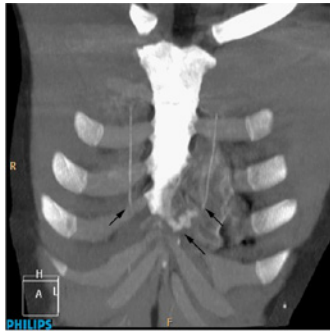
Coronal Reconstruction of the Repeat Thoracic CT Scan: This reconstructed, contrast-enhanced computed tomography of the thorax demonstrates bilateral internal thoracic artery injury with contrast pooling (arrows). (Philips 64 slice scanner 64 x 0.625 detector array, C filter, 3mm thickness by 1.5mm spacing or increment).
